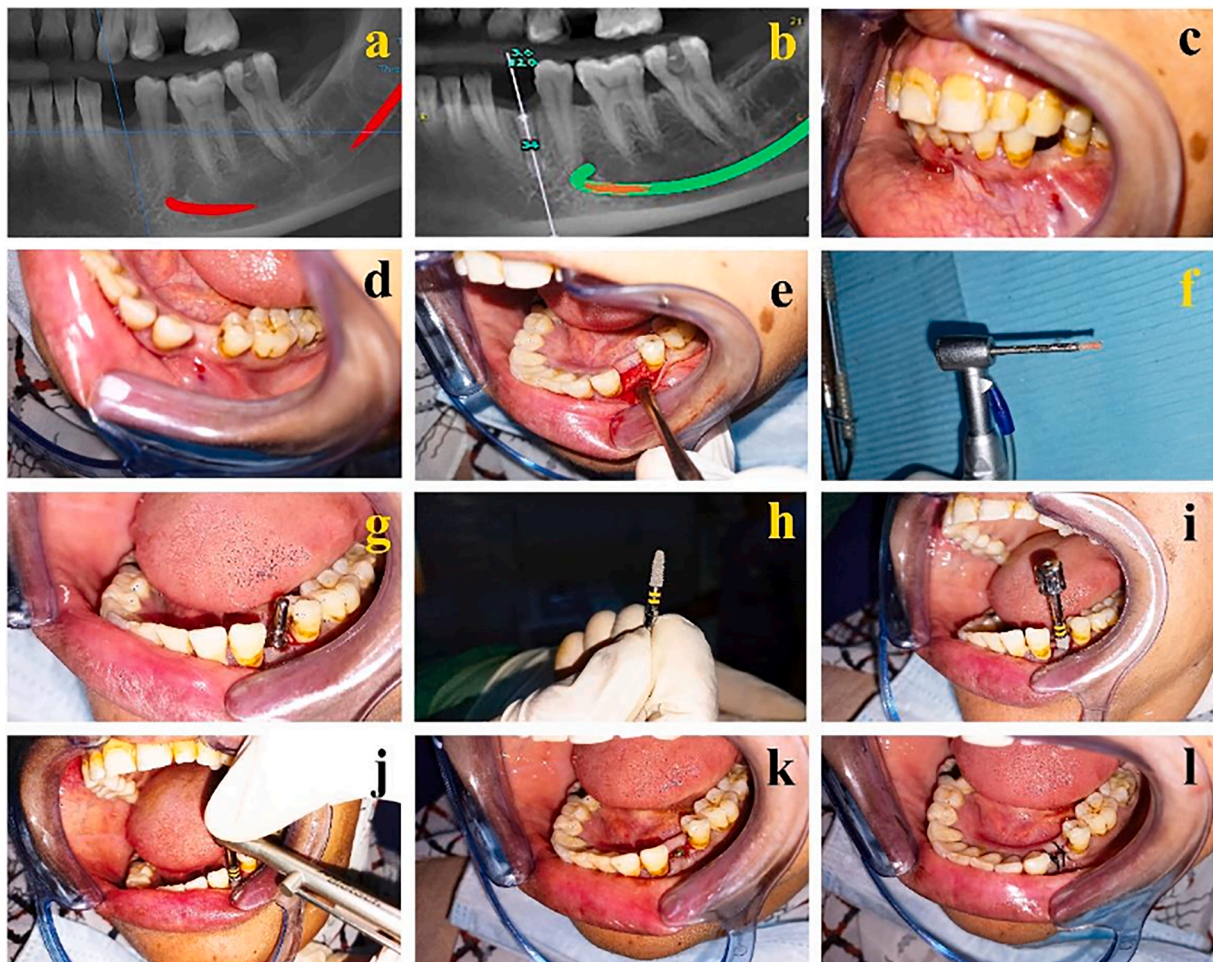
Three-month surgical follow-up for implant implantation and bone core biopsy: (a) Three-month pre-operative CBCT of the extraction site demonstrates full extraction socket healing; (b) CBCT showing the virtual implant prior to surgery at the extraction site; (c) pre-operative clinical image of the central occlusion's inter-occlusal area prior to implant implantation; (d) An intraoral picture showing complete mucosal healing following the initial premolar extraction and prior to implant placement; (e) reflection of a full mucoperiosteal flap; (f) biopsy of the bone core retrieved by the trephine bur from the enlarged area prior to implant site preparation; (g) A parallel pin demonstrating the implant's parallelism to the surrounding teeth; (h) NeoBiotech tapered resorbable blast media (RBM) dental implant's macrostructure (3.5 × 11.5 mm); (i) implant inserted into the osteotomy site; (j) complete implant placement utilizing a manual torque wrench in the osteotomy site; (k) cover screw placed over the dental implant before closure of the flap; and (l) Sutured and relocated mucoperiosteal flap. Reprinted with permission from [Ghanem et al., 2022](#).
